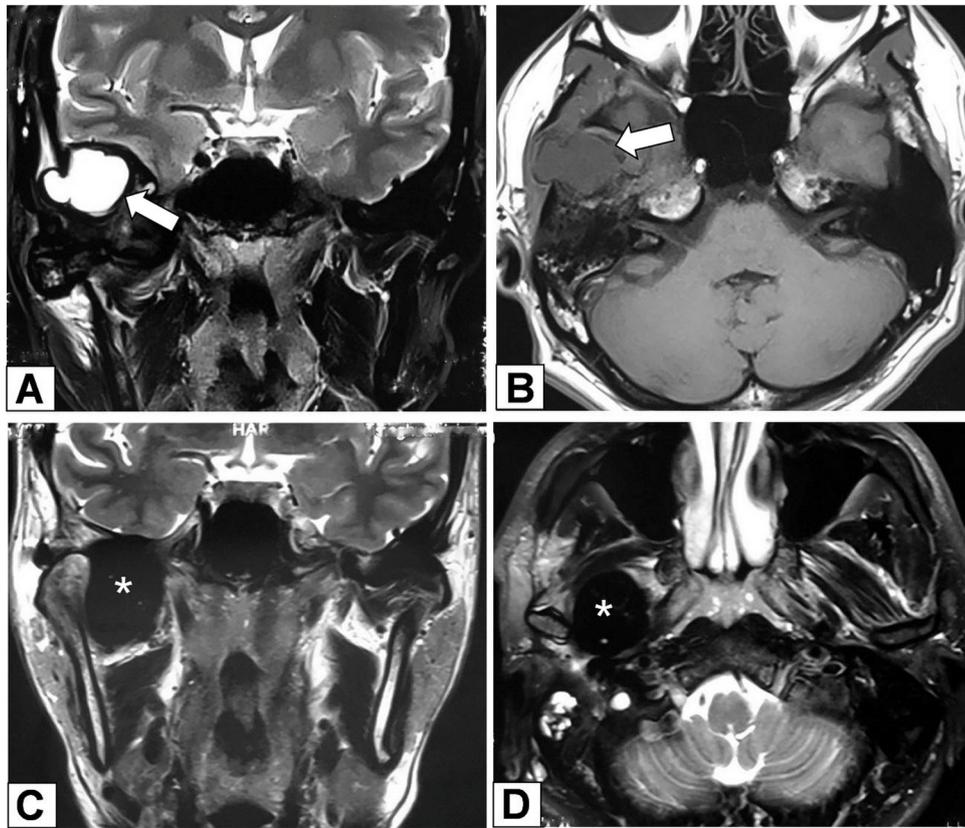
MRI images of a recurrent diffuse tenosynovial giant cell tumour involving the right TMJ in a 27-year-old man. Images of the primary tumour revealing a predominant hypointense lesion with local cyst-like changes (white arrow) on T2-weighted imaging (A) and T1-weighted imaging (B). A recurrent hypointense lesion (white asterisk) was observed on T2-weighted imaging (C) and T2-weighted imaging (D) 10 months later.
